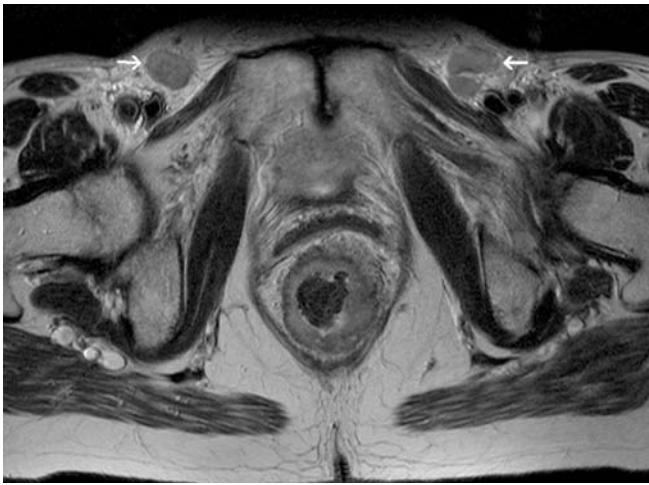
Axial T2-weighted FSE (TSE) sequence. Inguinal lymph node metastases (*arrows*) in a patient with low rectal cancer
